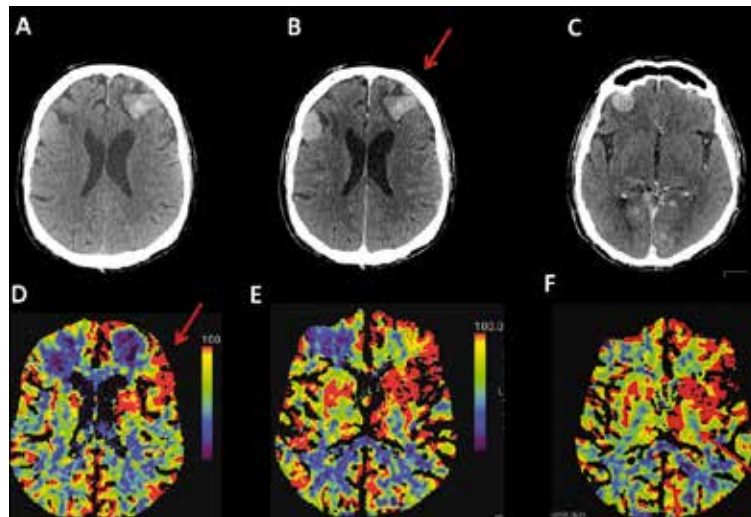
67 year old male, malignant melanoma, cerebral metastasis, no reaction to speech since 2 hours, spasticity on the right, anisokoria of pupils, clinical diagnosis of NCSE. A- CT unenhanced B/C and after contrast showing multiple metastasis and hemorrhage in one metastasis left frontal, D-F hyperperfusion of the left Insula and left frontal lobe, left thalamus and basal ganglia. Complex situation, in spite of multiple intracranial metastasis with acute hemorrhage frontal left, perfusion imaging detects hyperperfusion in a cortical distribution involving basal ganglia associated to ongoing epileptic activity. The hyperperfusion is distinct from tumor related hyperperfusion by its distribution and intensity in this case.
